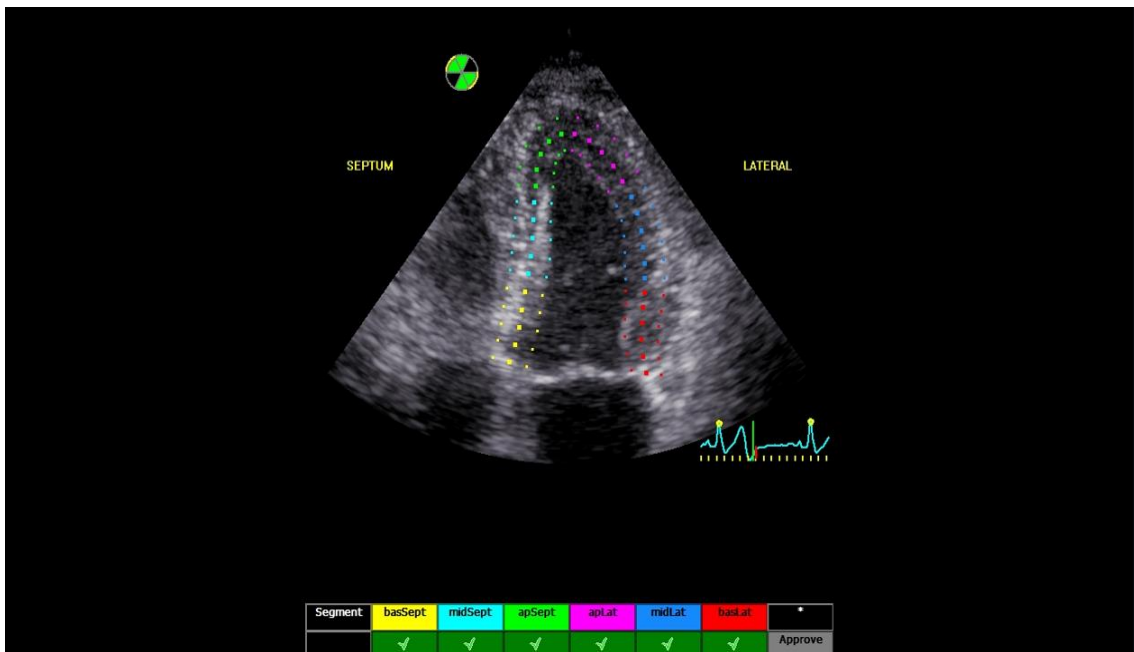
Fourth, segmental strain in the apical 4-chamber view is quantified. Adjustments in the automated speckle-tracking contour are made if necessary.
